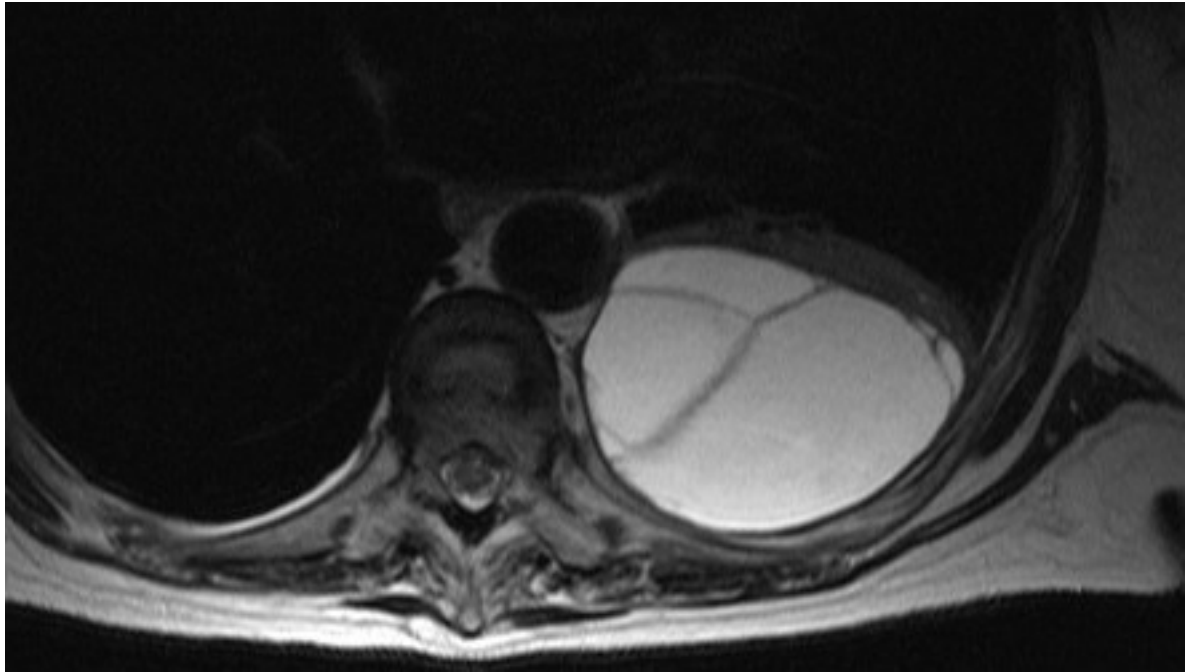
CT scan of thoracic empyema*
